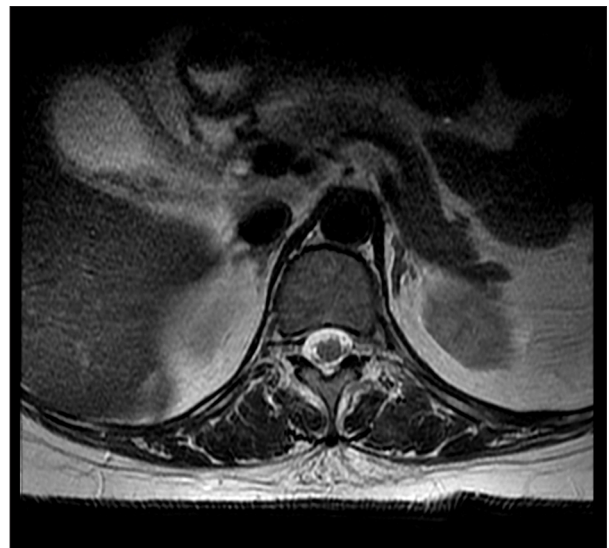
Axial T2-weighted MRI image confirms the regression of the intramedullary diffuse T2 conus lesion.
